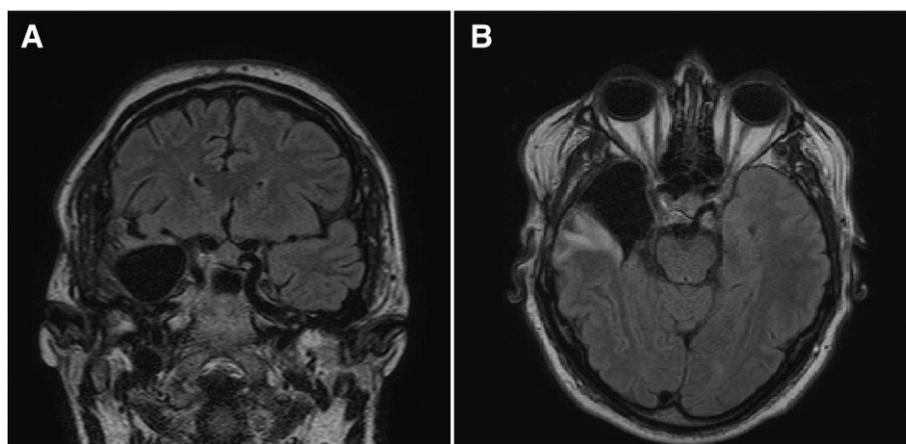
Postsurgical sequelae associated with right temporal resection in (A) coronal and (B) axial FLAIR images.
